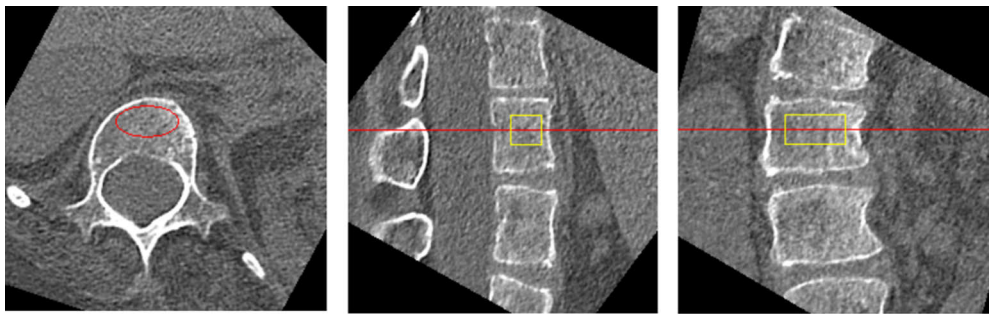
BMD measuring with QCT software. Defined ROI areas defined in red and yellow on CT images. Published in study IV.
